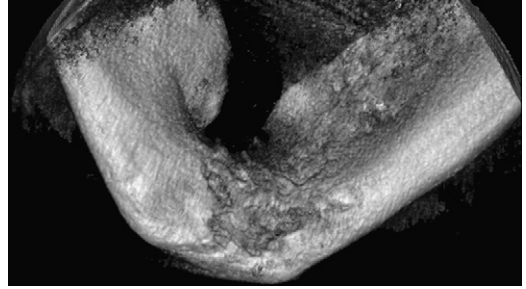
Sagittal cone beam CT showing mandibular symphysis osteomyelitis.
